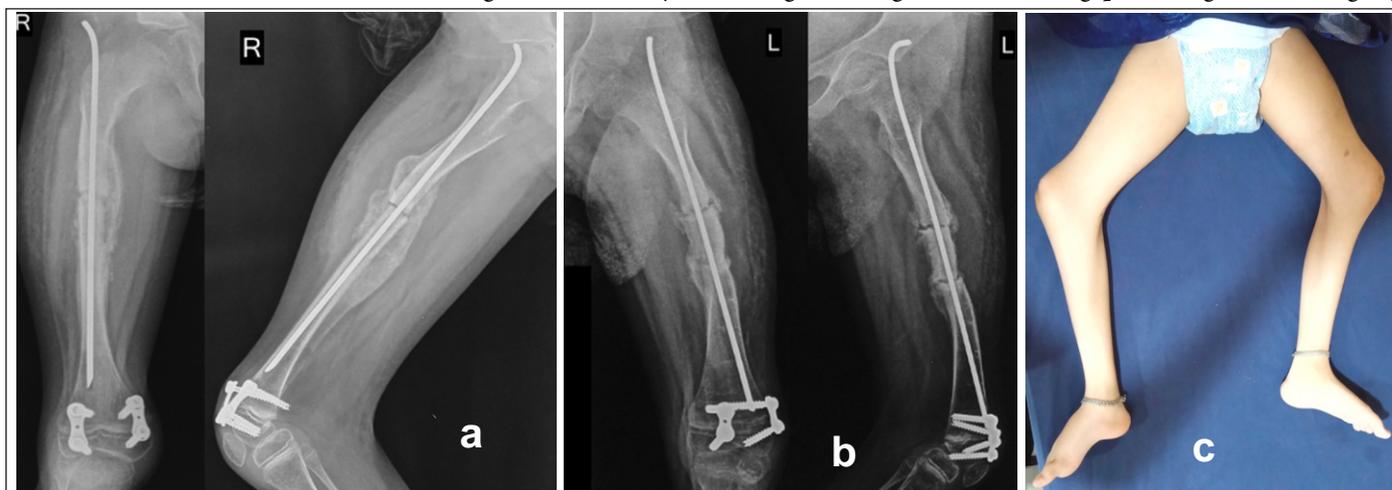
Clinical pictures and radiographs after surgery.
